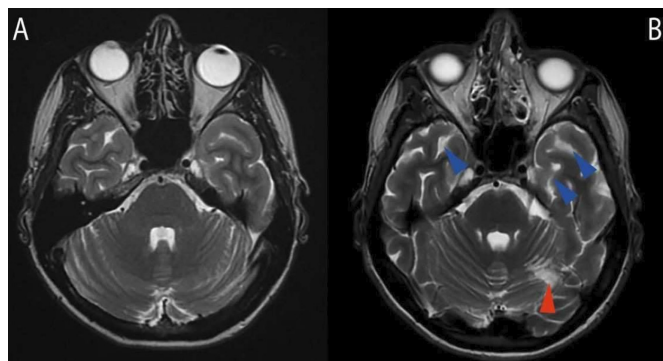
(A) Axial T2-weighted MRI at baseline, showing no structural changes. (B) Follow-up axial T2-weighted MRI demonstrating bilateral temporal lobe atrophy (blue arrowhead) and post-ischaemic encephalomalacia in the left cerebellar lobe (red arrowhead).
